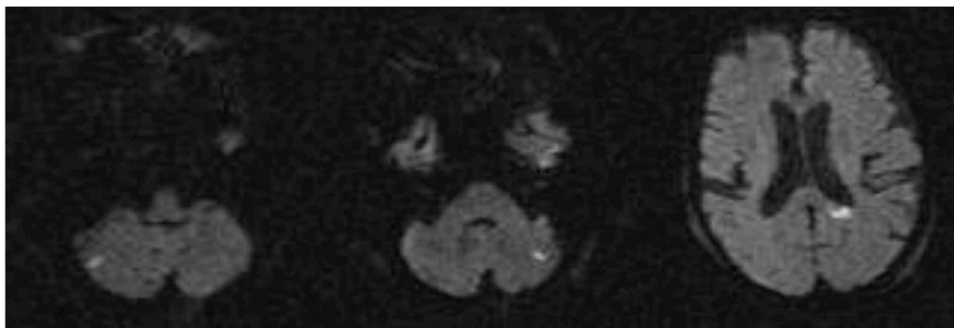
Preoperative diffusion-weighted MR images of the brain. Some small infarctions were located in the territory of the posterior cerebral artery or posterior inferior cerebellar artery.
